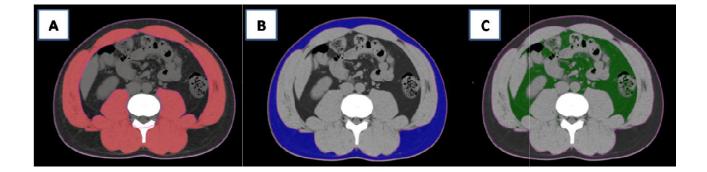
Cross-sectional computed tomography at the level of the third lumbar vertebra. (A) Skeletal muscle areas were identified and quantified by using a computed tomography attenuation value of - 29 to 150 HU. (B) SAT areas were quantified by using attenuation values of -190 to -30 HU. (C) VAT areas were quantified by using attenuation values of -150 to -50 HU. HU, Hounsfield units;. (from [38,39])
